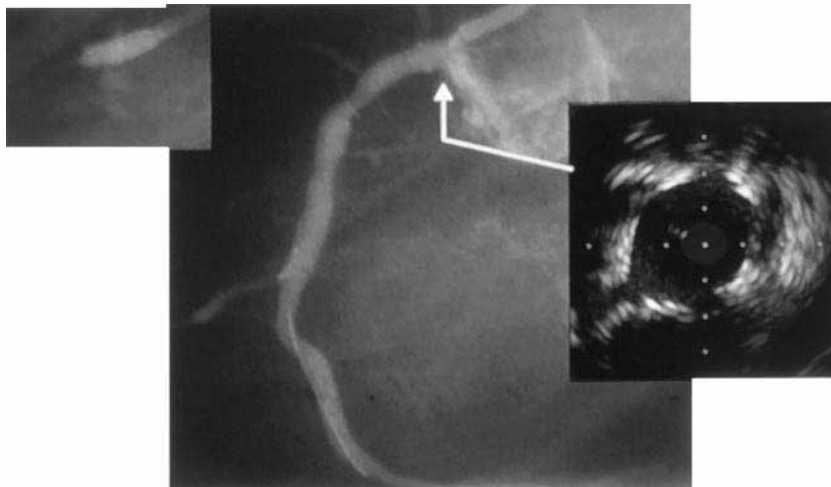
Based on this ultrasound evaluation, a Palmaz 104 biliary stent was placed on a 4.5-mm Chubby balloon and deployed at 14 atm at the ostium of the right coronary artery. The final angiogram shows an expanded ostium, and the ultrasound study shows that the lumen at the ostium is 3.5×3.0 mm.
